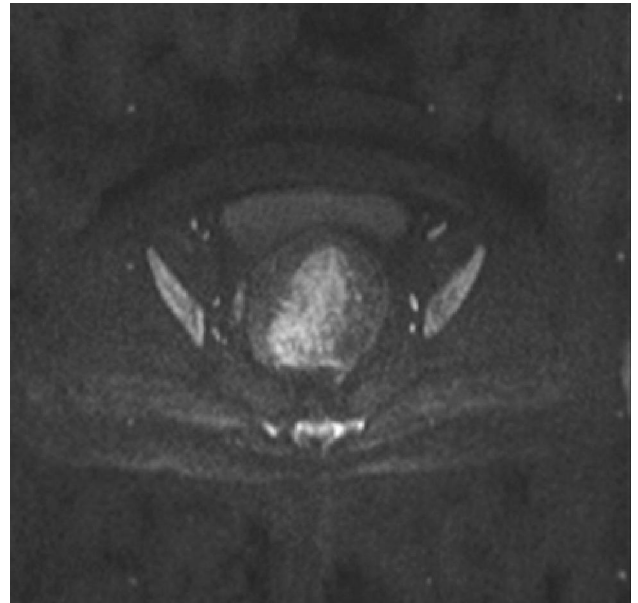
Negative on DWI
